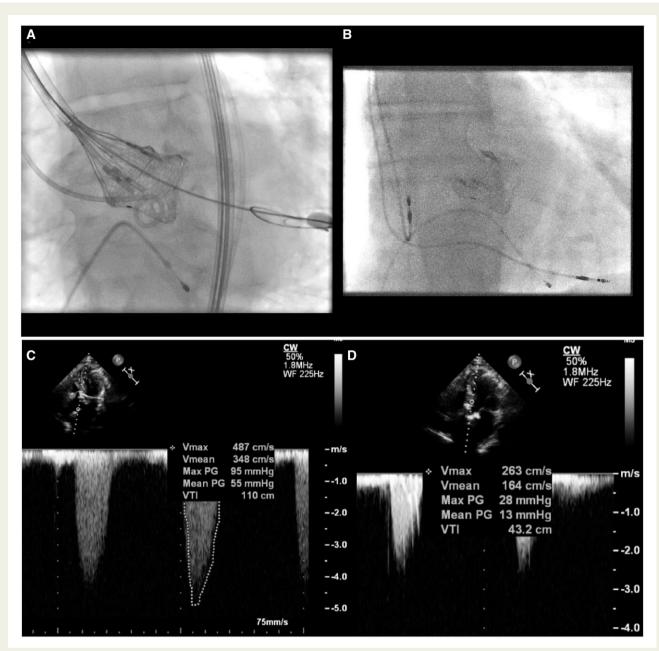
(A) Delivery of aortic prosthesis in the projected view. (B) Final result with dual-chamber pacemaker *in situ*. (C) Pre-procedural echocardiogram confirming severe aortic stenosis with peak velocity 4.9 m/s. (D) Echocardiography post-implant confirming reduction in peak aortic velocity to 2.6 m/s.
